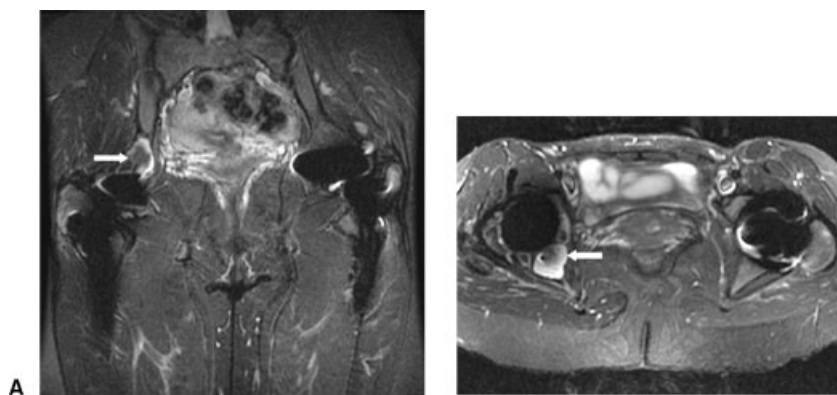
Coronal (A) and axial (B) STIR images (TR/TE, 4400/22 milliseconds; TI 150 milliseconds) of the right total hip arthroplasty demonstrate well-circumscribed focal lobulated areas of intraosseous increased T2-weighted signal change involving the medial and posterior walls of the acetabulum as well as the supra-acetabular region (arrows) consistent with osteolysis.
